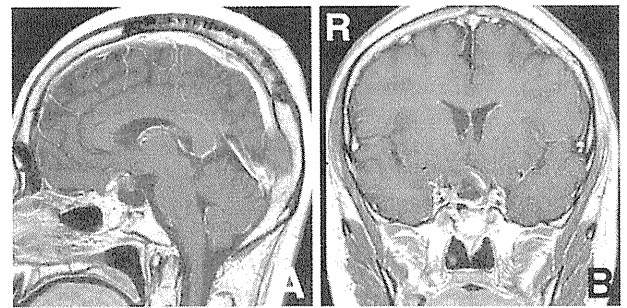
Postoperative sagittal (A) and coronal (B) T₁-weighted magnetic resonance images with gadolinium showing the small residual mass within the suprasellar region. The solid and cystic components within the sella turcica were totally removed.
